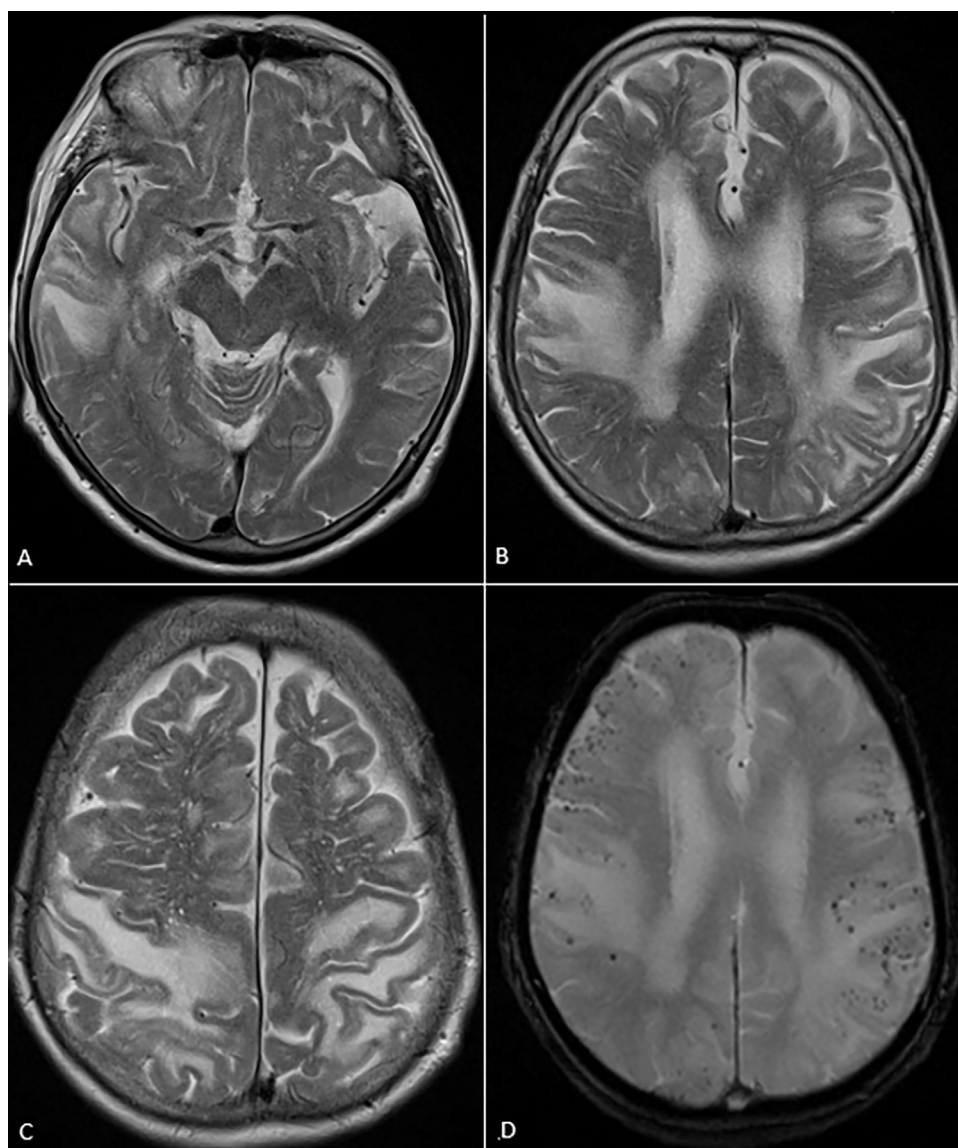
Second hospitalization – acute vasogenic edema of right temporal lobe and diffused hyperintensive changes on T2-weighted images (A–C), diffused subcortical microhemorrhages with hemosiderine deposits in SWI option (D).
